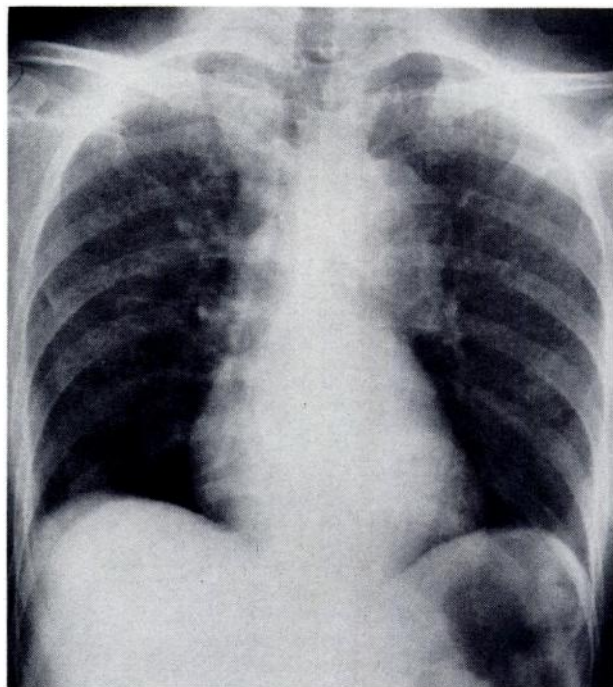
The chest x-ray film on admission. Cardiac size and configuration are within normal limits.
